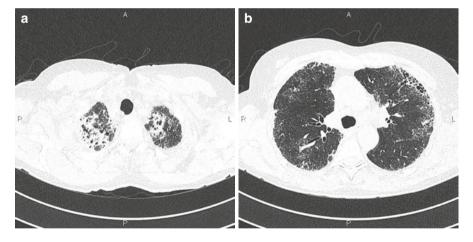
(a) HRCT of the lungs: bilateral peribronchial multiple regions of consolidations, with a preserved air bronchogram. (b) HRCT of the lungs: bilateral reticulations, peribronchial multiple regions of GGO. (c) HRCT of the lungs: especially bilateral subpleural reticulations, and traction bronchiectasis. (d) HRCT of the lungs: bilateral subpleural reticulations, and traction bronchiectasis
